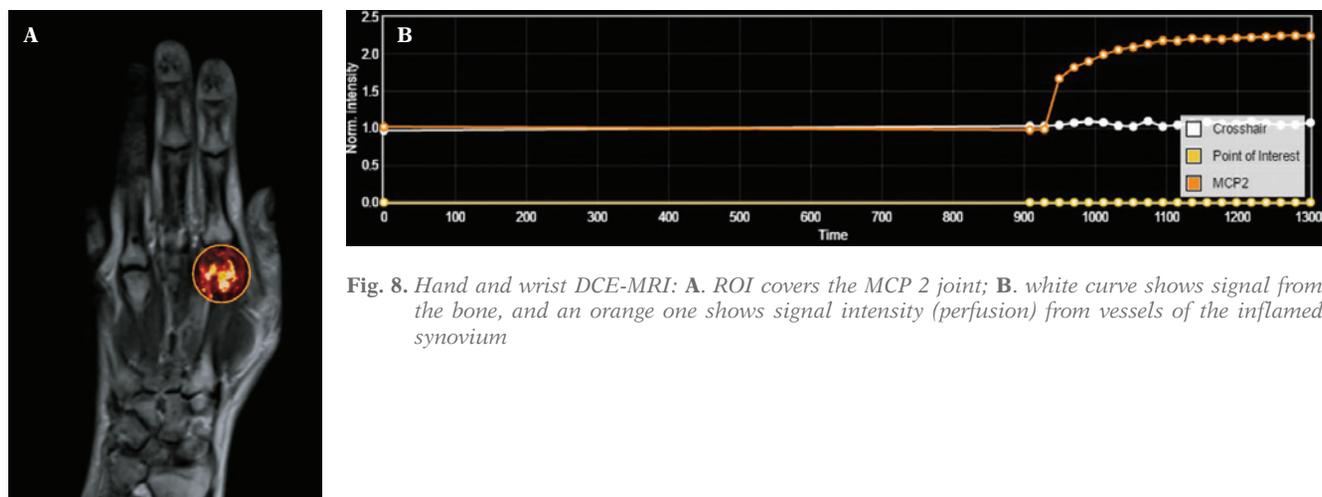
Hand and wrist DCE-MRI: A. ROI covers the MCP 2 joint; B. white curve shows signal from the bone, and an orange one shows signal intensity (perfusion) from vessels of the inflamed synovium
